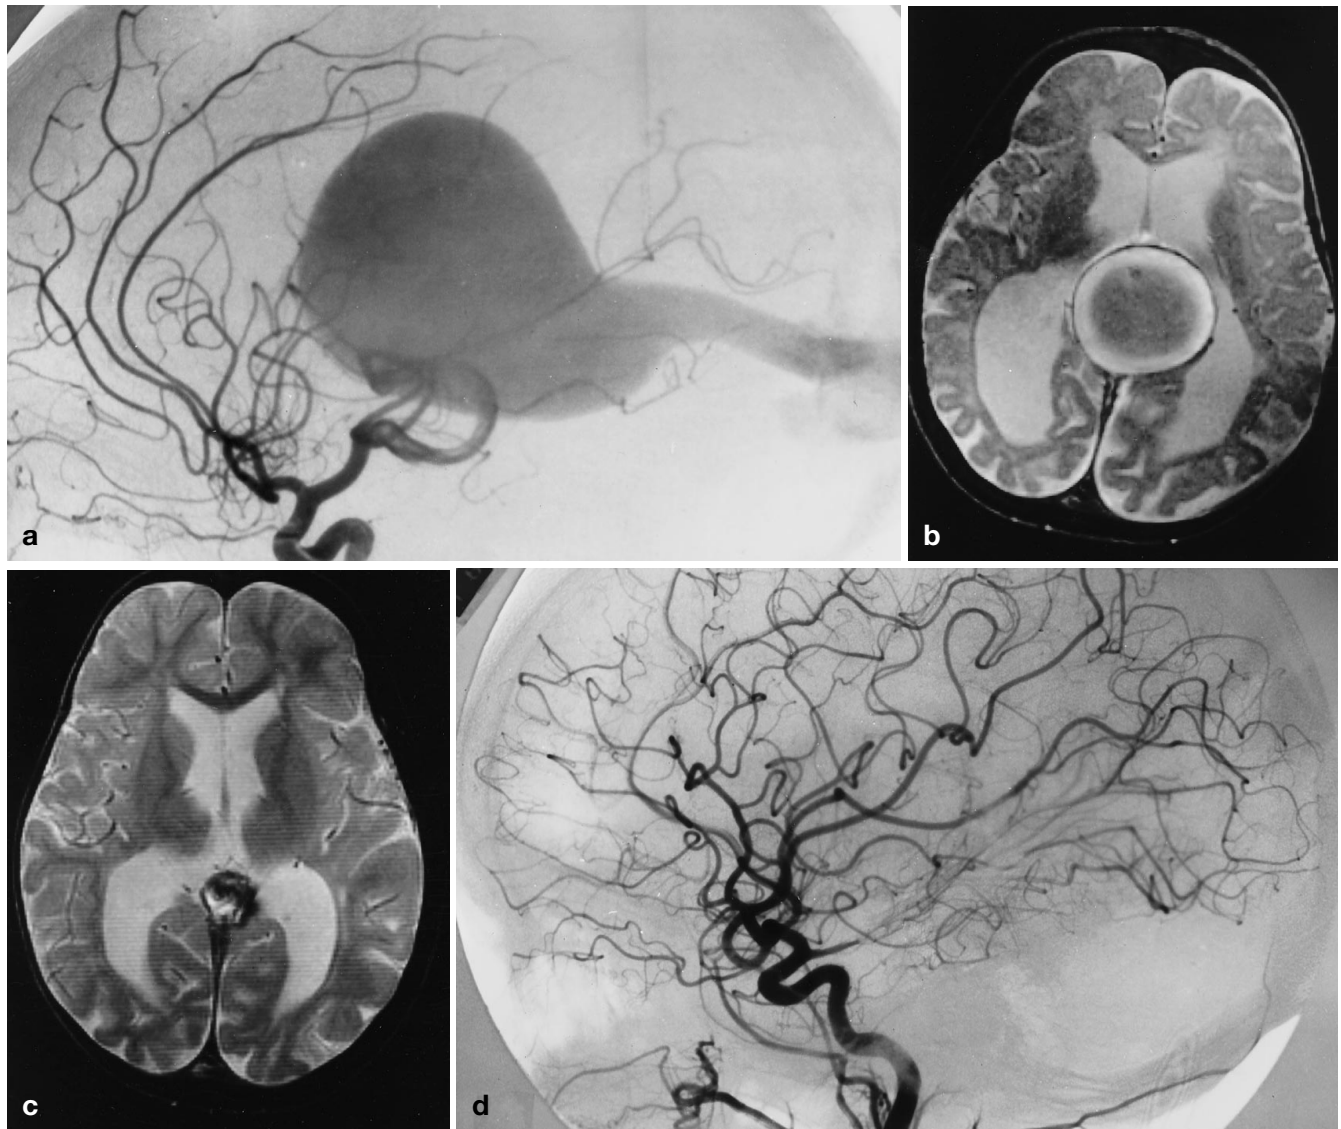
Patient 2. VGAM diagnosed at 8 months of age. a Pre-embolisation right internal carotid angiogram at 10 months, confirming a mural VGAM. b Axial T2-weighted image 2 weeks after embolisation at 12 months. Normal brain parenchyma, but enlargement of the lateral ventricles persists. c Image following embolisation at 37 months. Complete occlusion and regression of the VGAM. Lateral ventricles are smaller; normal brain parenchyma. d Follow-up internal carotid angiogram: complete occlusion of the VGAM
